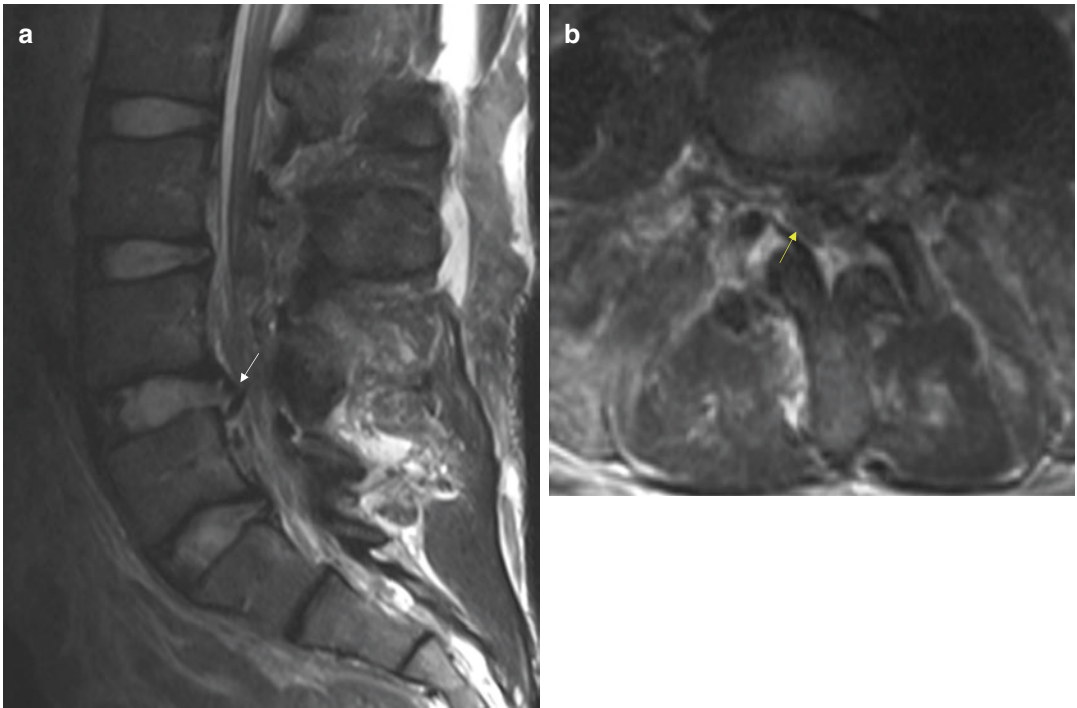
(a) Sagittal T2-weighted image demonstrates posttraumatic disc herniation at L4 effacing the thecal sac (white arrow). (b) Axial T2-weighted image at the same level demonstrates combination of disc herniation and epidural hemorrhage significantly displacing and compressing the cauda equina, denoted by the yellow arrow
